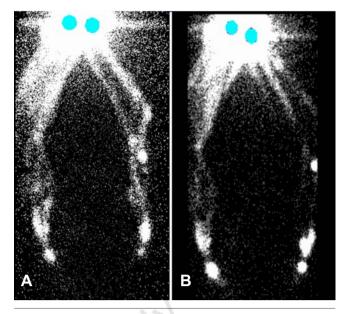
Lymphoscintigraphic image before (A) and after (B) a single manual passage in the limb using manual lymphatic therapy with linear movements indicated for primary lymphedema.
